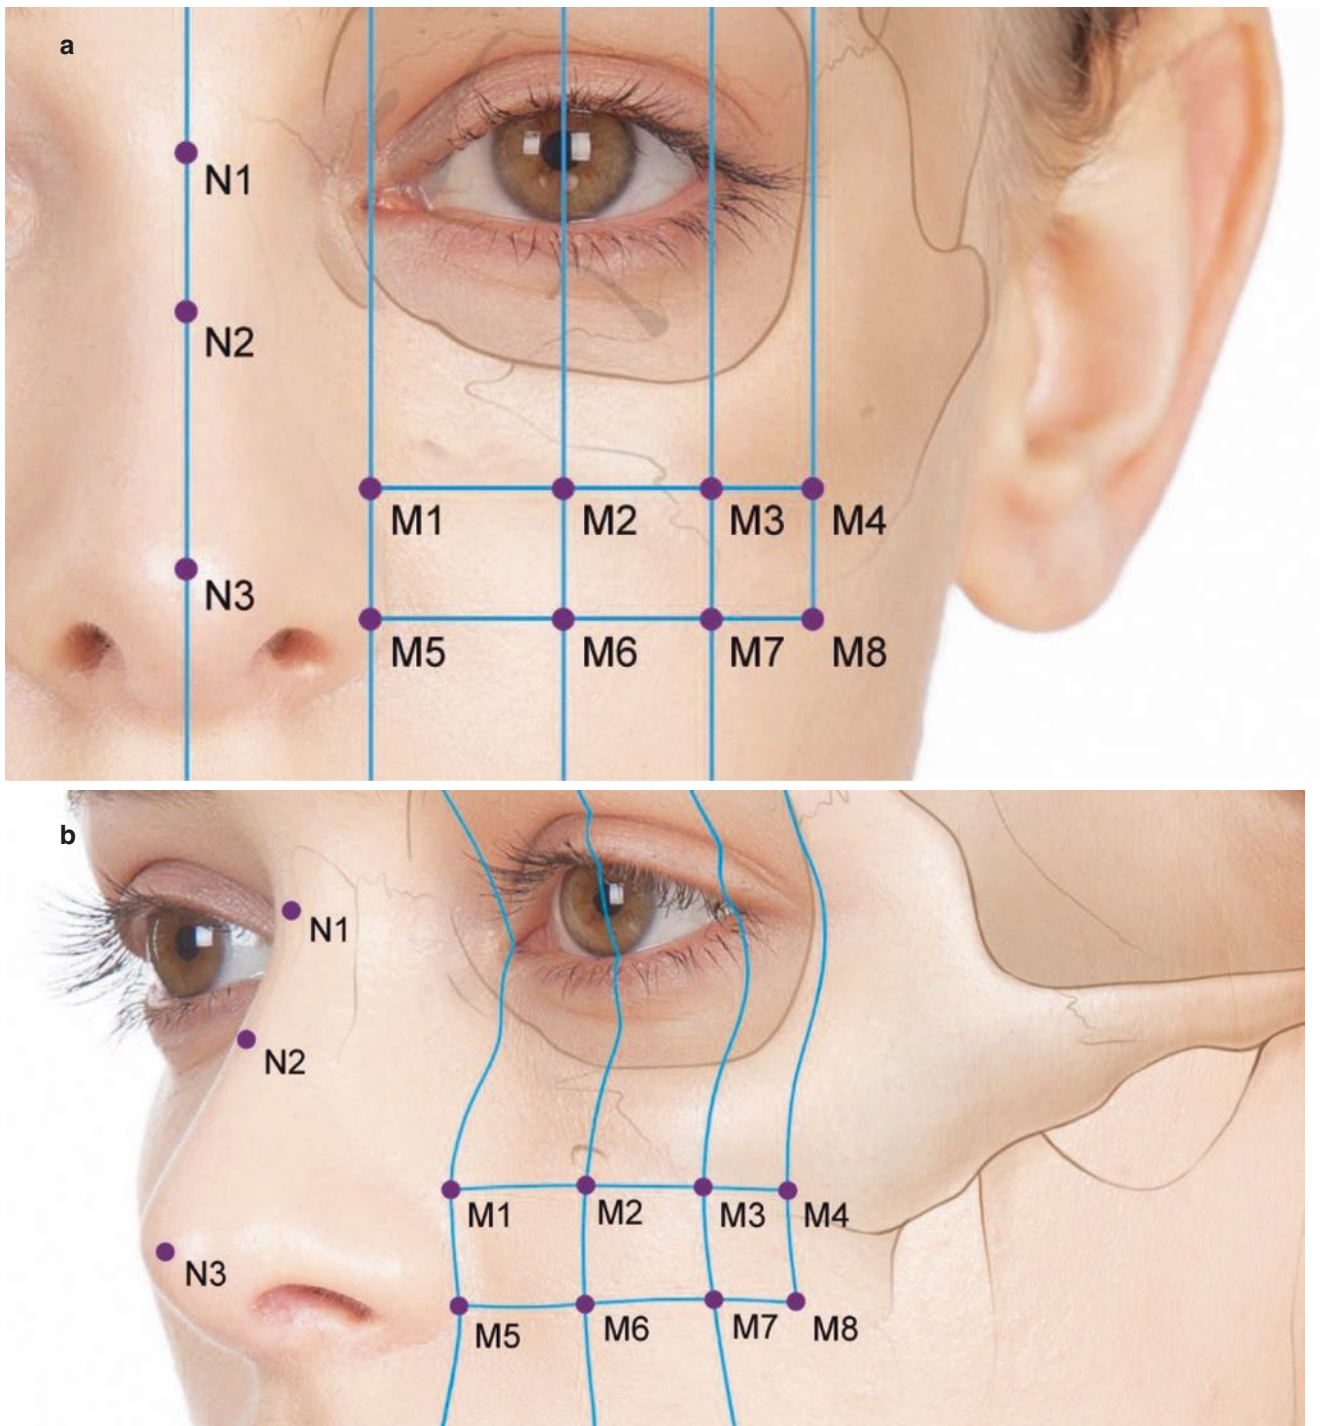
Facial landmarks and reference lines for the ultrasonographic examination of the midface and nose. (a) Frontal view and (b) oblique view. (Published with kind permission of © Kwan-Hyun Youn 2020. All Rights Reserved)
